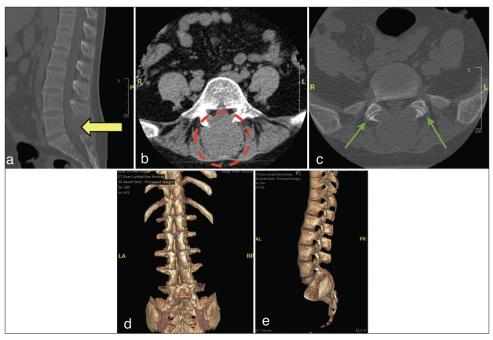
Computed tomography (CT) scan lumbosacral without contrast (a) sagittal L5 showed processus spinosus destruction (yellow arrow), (b) axial L5 showed lamina and processus spinosus destruction (red-dotted circle), (c) axial L5 showed facet joint (green arrow) and CT scan 3D bone reconstruction (d) lateral view, (e) posterior view.
